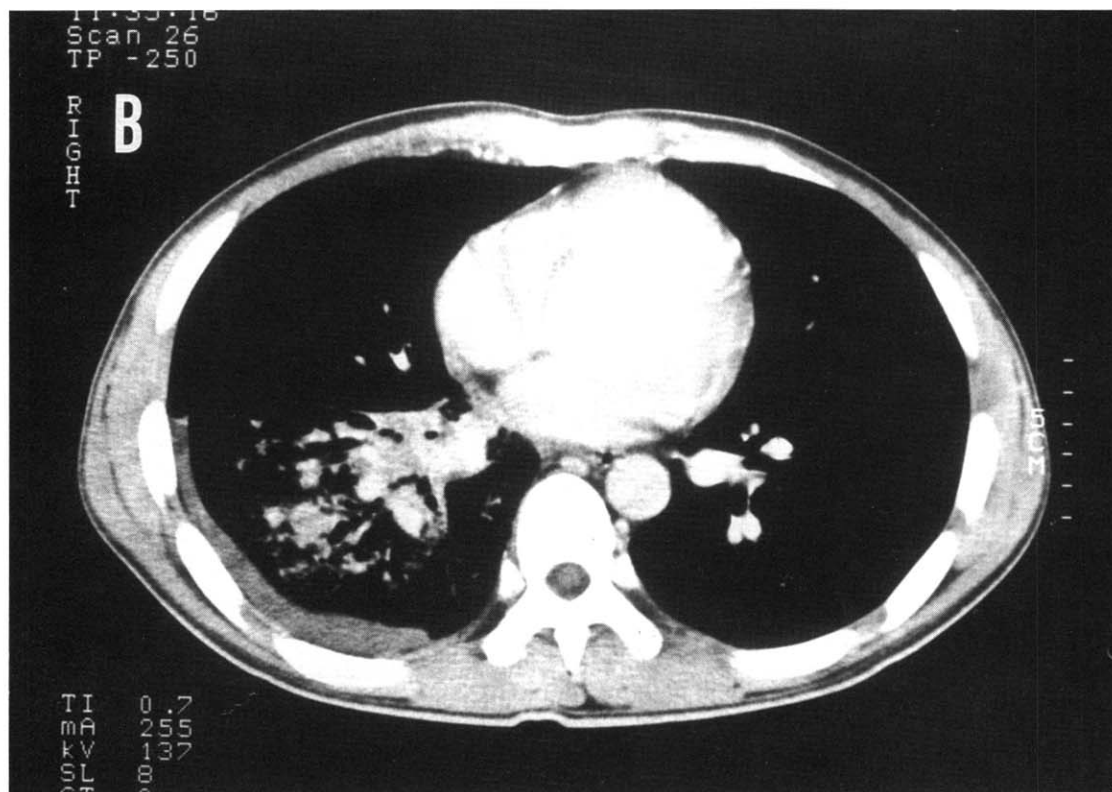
PA chest radiograph(A) and computed tomography scan of the chest(B) demonstrating pleural effusion combined with consolidation and partial atelectasis on right lower lung field.
